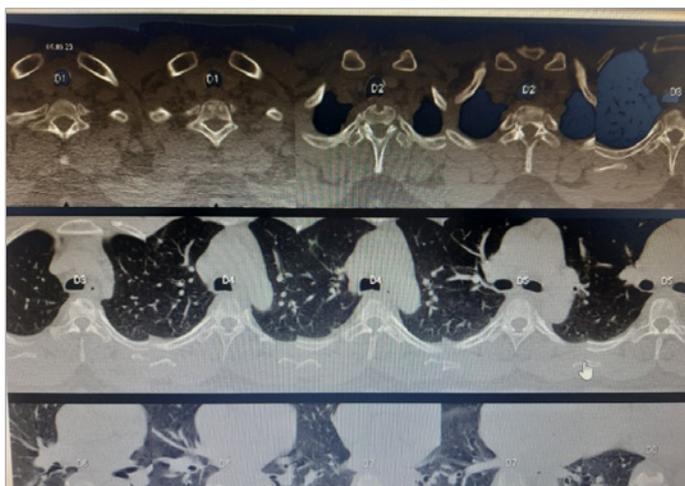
Gopalakrishnan CT\_September\_23.
